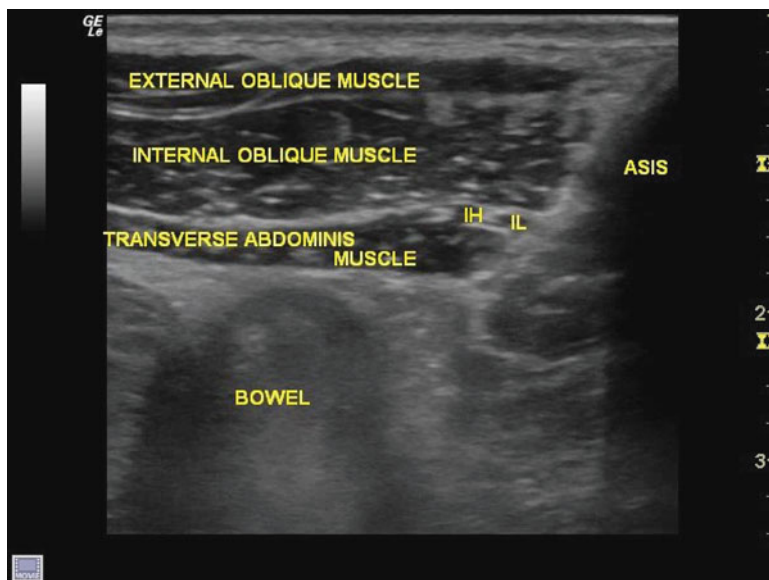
Ultrasound image of iliohypogastric (IH) and ilioinguinal nerves. Please note the proximity of the bowel (ASIS anterior superior iliac spine)
